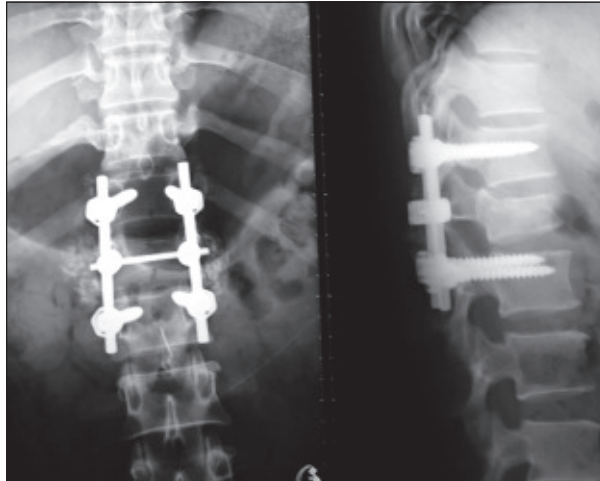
Post operative X-Ray A/P & Lateral View
